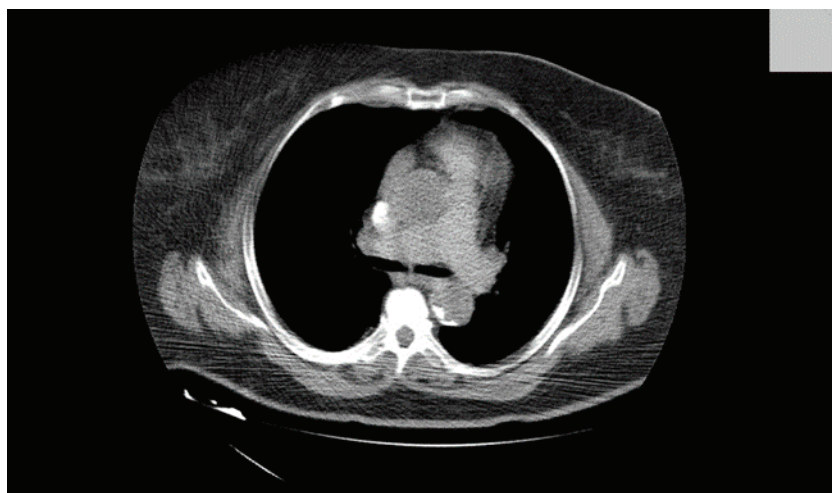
Thromboembolism shown on CT with contrast.
